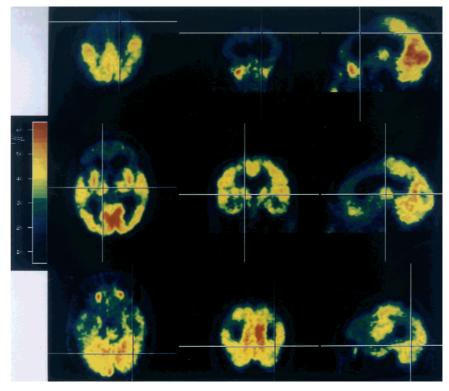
FDG-PET image of patient 1: Representative transaxial (left column), coronal (middle column), and sagittal slices (right column). Right brain side is on the left and vice versa.
